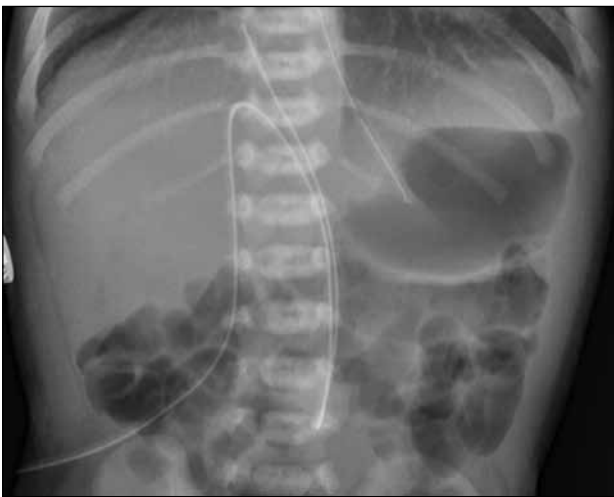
An abdominal radiograph on the day of umbilical venous catheter (UVC) insertion showing UVC position in the expected position of inferior vena cava and right atrial junction. A feeding tube has also been introduced.
